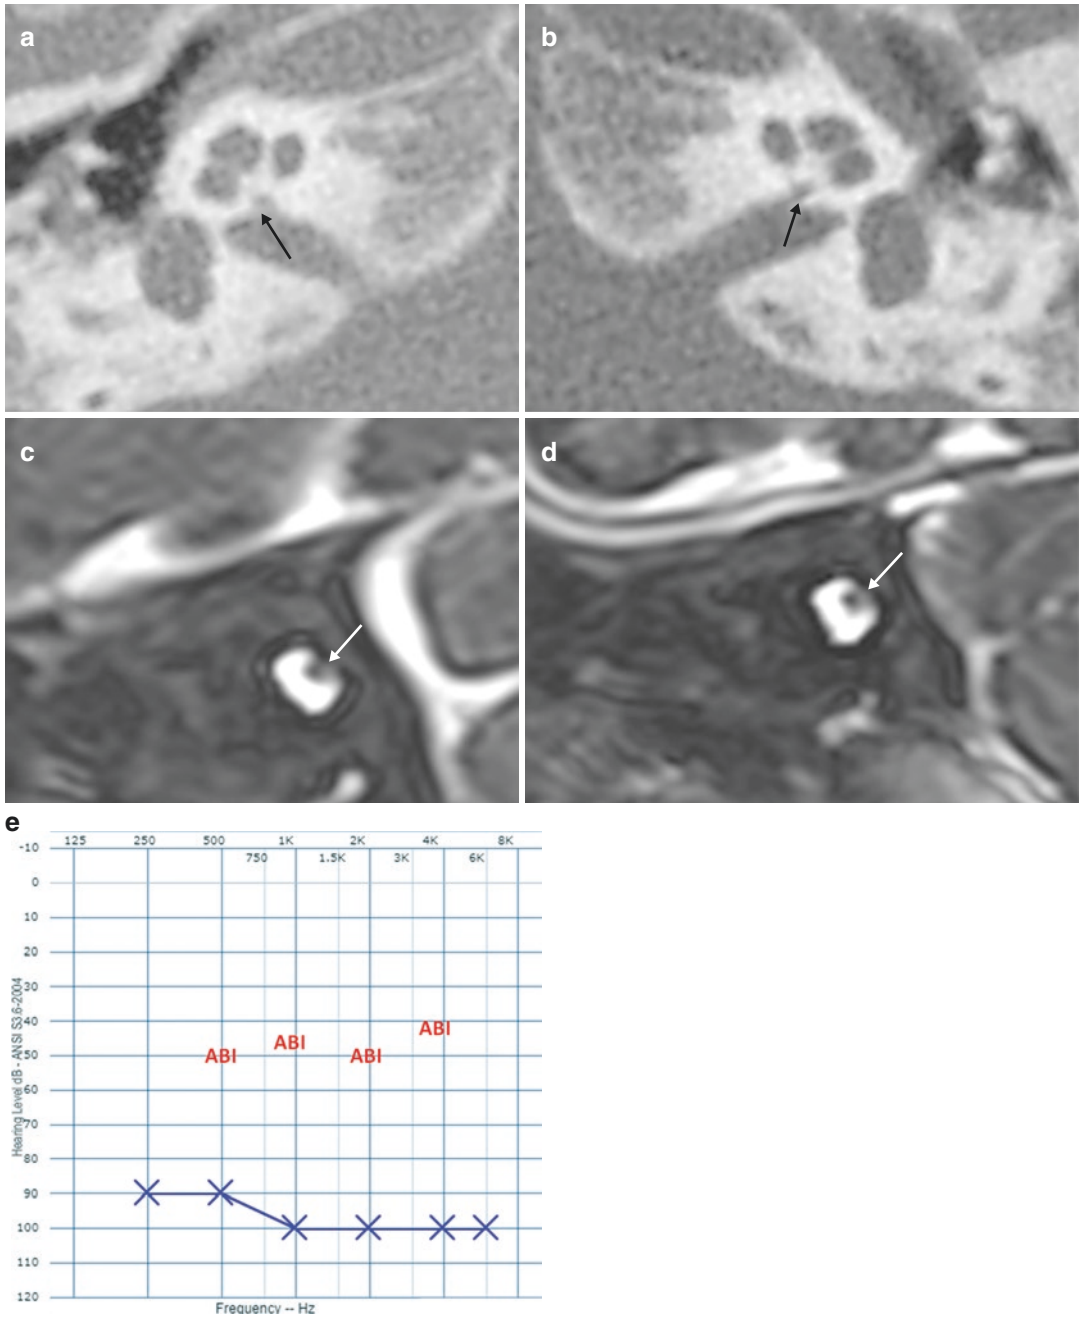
Case 1. Temporal bone CT axial mid-modiolar section showing bilateral cochlear hypoplasia type III, bilateral CA stenosis (a and b) and sagittal oblique section
